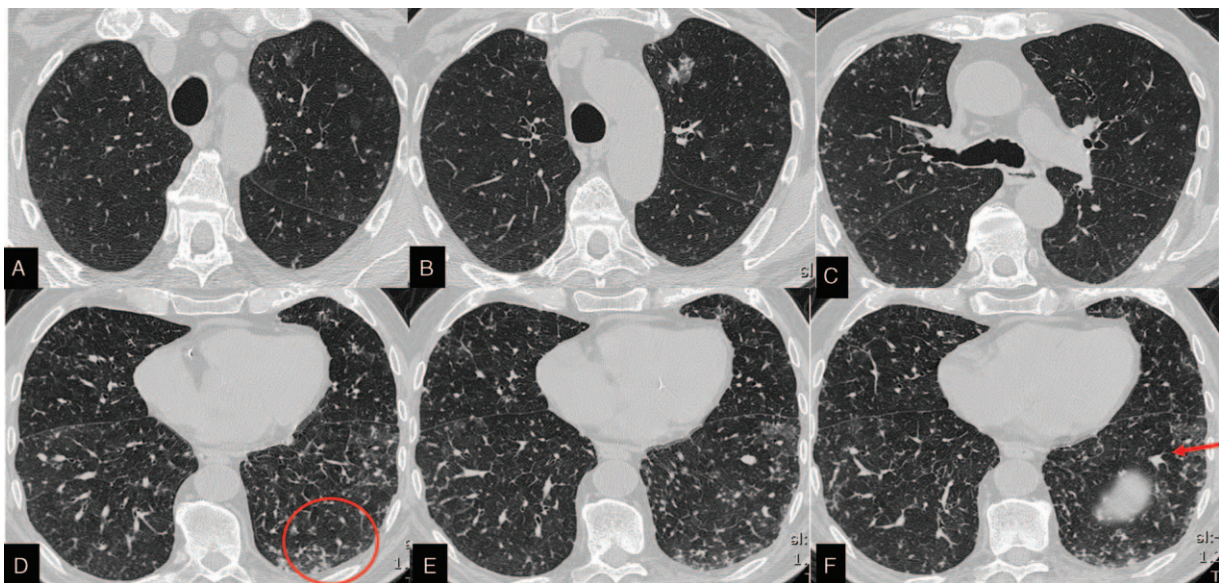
Patient 1. CT scan shows numerous bilateral tiny nodules mainly in the middle and lower zones of hemithoraces. Many of these nodules show a vascular tree-in-bud pattern related to neoplastic thrombotic microangiopathy (red circle). Moreover vascular branches are focally enlarged. This finding is particularly evident in the left lower lobe (red arrow). A mild smooth thickening of interlobular septa is also present in both lower lobes.
